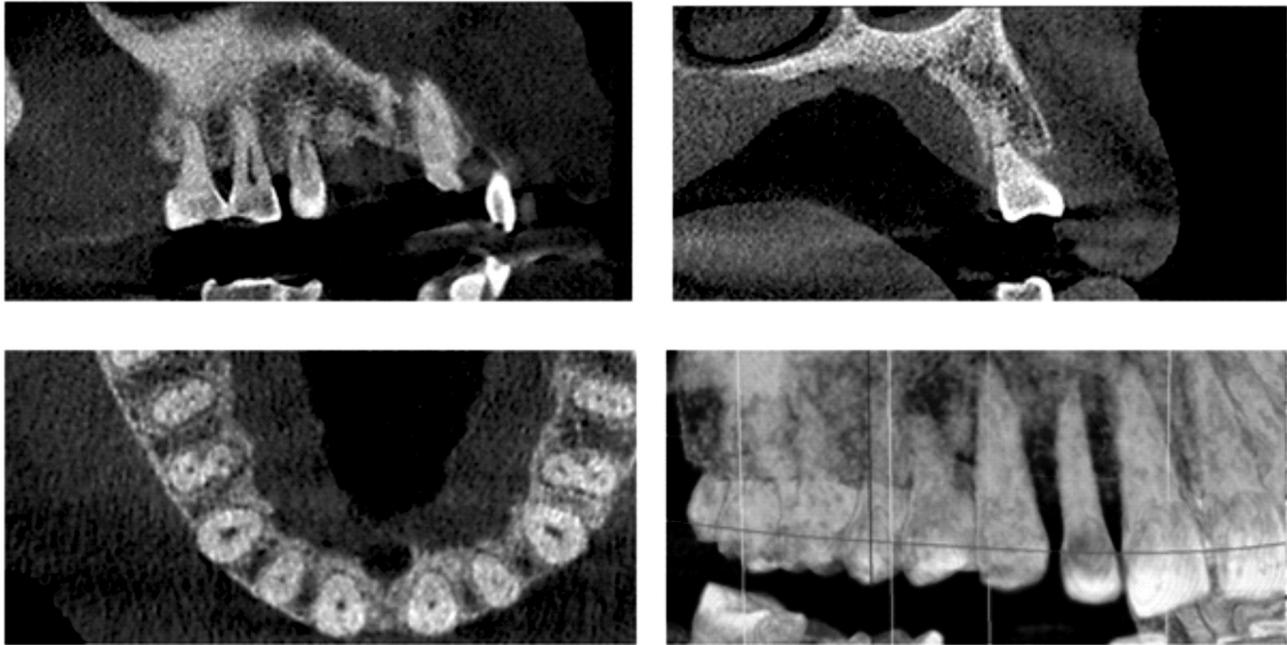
Cone beam computed tomography showing healing of the fractured segment without any signs of pathology
